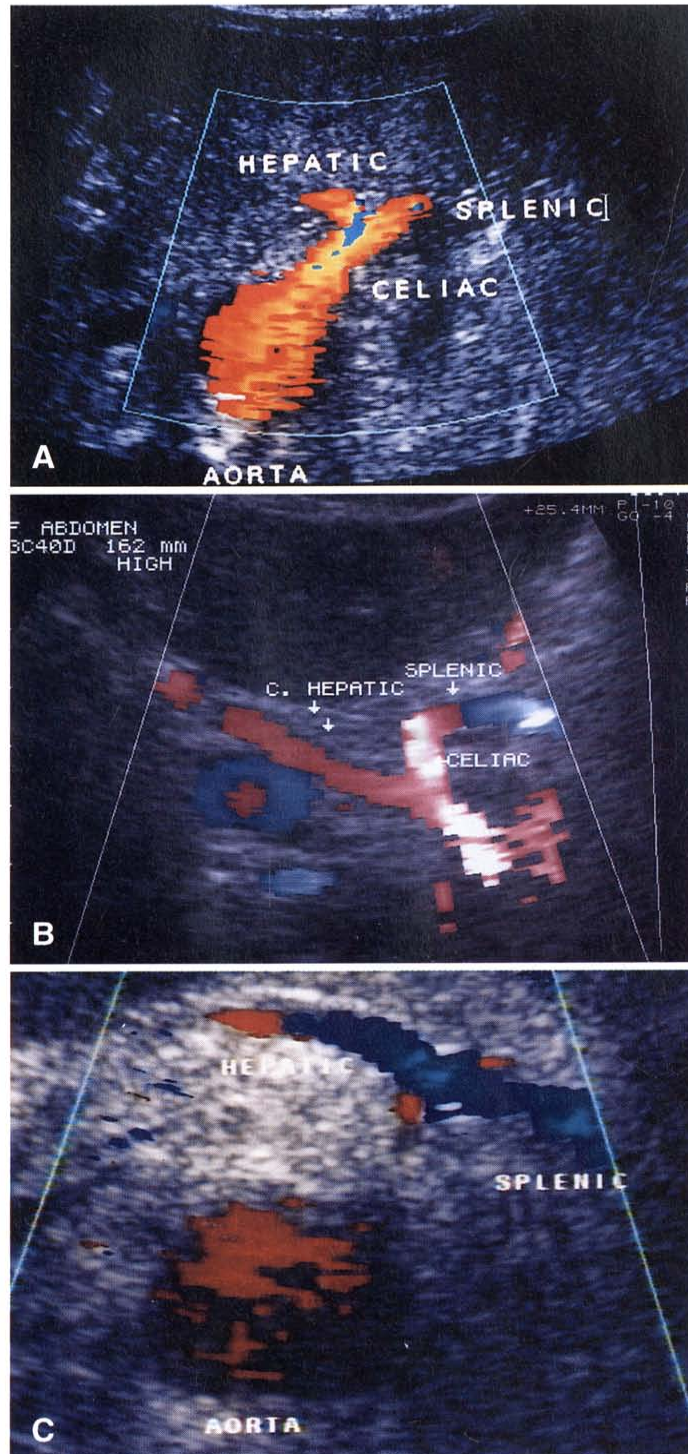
Colorflow duplex appearance of aorta and celiac axis in transverse image plane. A, Antegrade blood flow in celiac artery fills origins of the common hepatic and splenic arteries. B, Normal celiac bifurcates into common hepatic and splenic arteries, with antegrade blood flow in each branch identified by red color tag identifying flow towards the transducer. Bifurcation of celiac is the “seagull sign” used by sonographers. C, In case of occluded celiac, aorta is visible, but one cannot identify flow in location where celiac should be. Blood flow in common hepatic and splenic is in same direction, away from the duplex probe, as signified by uniform blue color assignment and confirmed by Doppler. This should not be the case if flow were traveling through a patent celiac into the two main branches. Findings predict a severe CA stenosis or complete occlusion.
